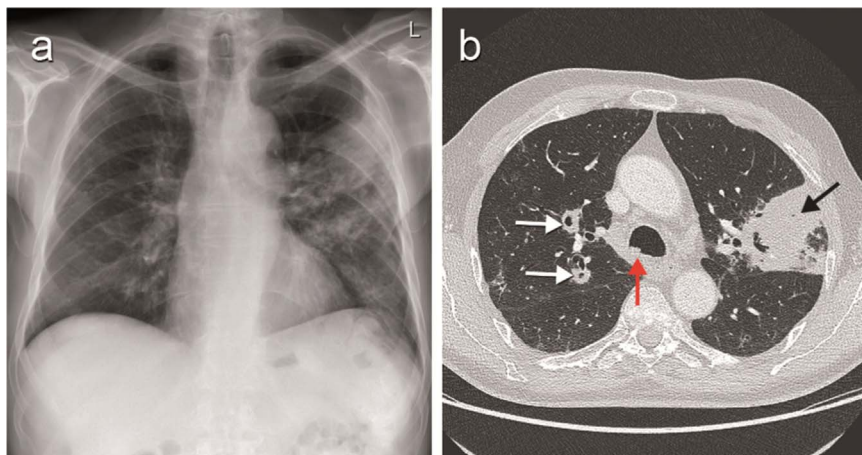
a: Chest radiograph showing opacities in the left upper lobe, lingula and lower lobe. b: Contrast-enhanced computed tomography of the chest showing left upper lobe consolidation (segment 2, black arrow), right upper lobe cavities within foci of consolidation, measuring up to 1.5 cm in diameter (white arrows), and irregularities of the posterior tracheal wall (red arrow).
